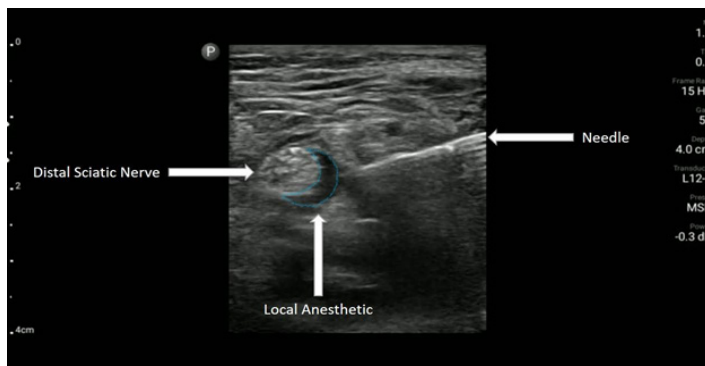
Ultrasound image showing the distal sciatic nerve with surrounding local anesthetic and needle visualized using an in-plane approach.
